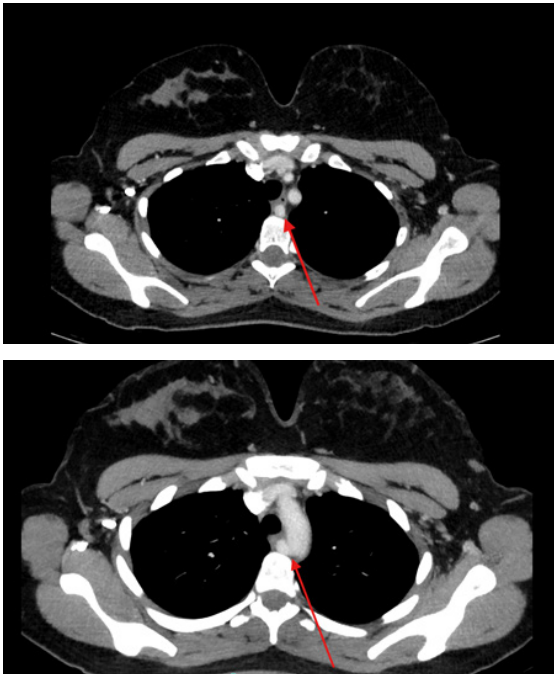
Contrast-enhanced axial CT of the thoracic inlet. Sequential axial images (arrow) showing an aberrant right subclavian artery arising as the last branch of the aortic arch and coursing posterior to the esophagus toward the right upper limb — the radiologic hallmark of *arteria lusoria*.
